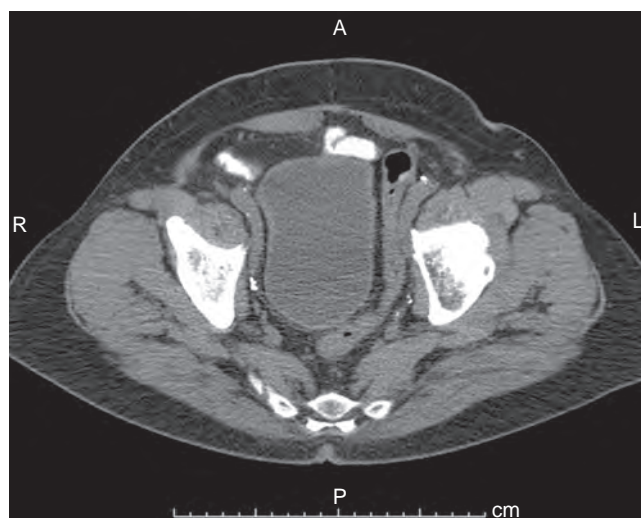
Computed tomography scan of the pelvis after construction of an ileal neobladder (Studer pouch) showing the spheric shape achieved by 1 year.
